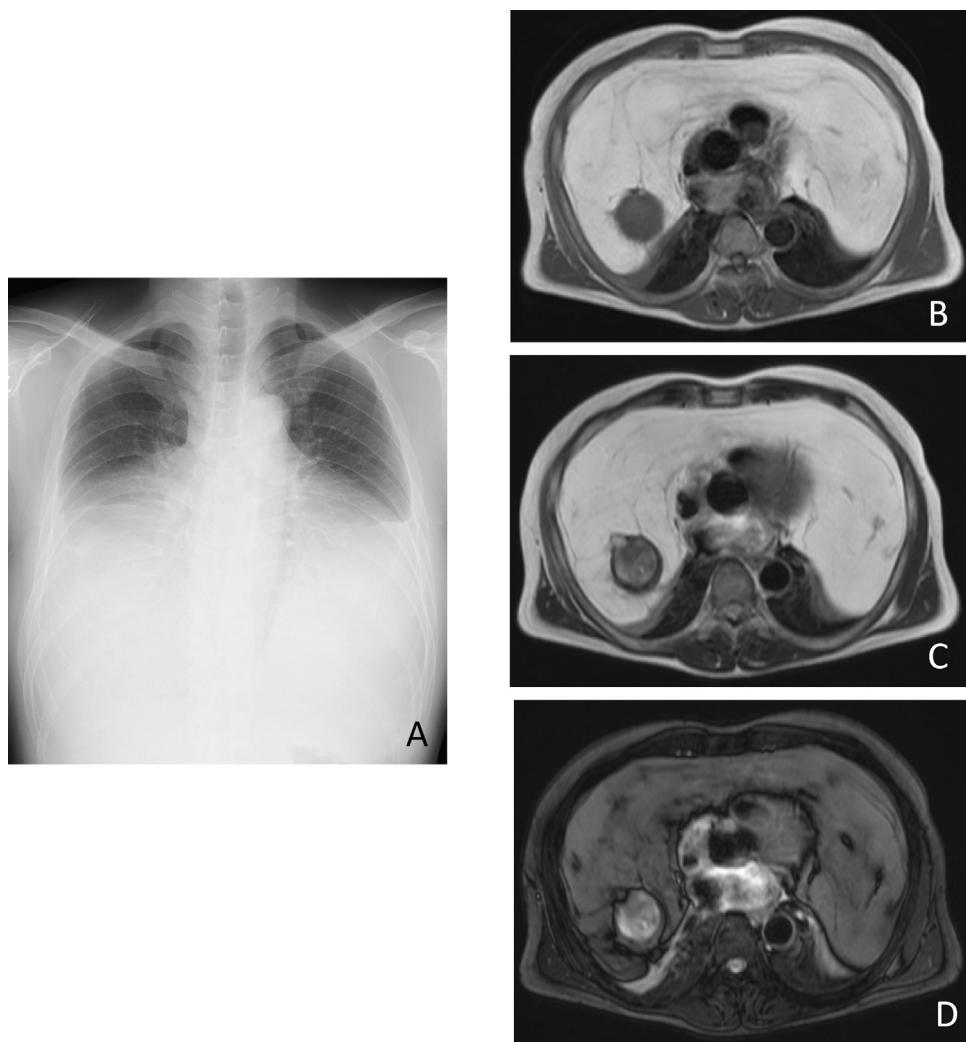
Chest radiography (A) showed remarkable cardiomegaly. T1-weighted image (B), T2-weighted image (C) and fat suppression T2-weighted image of magnetic resonance revealed a giant anterior mediastinal tumor with fat component, suggesting liposarcoma.
